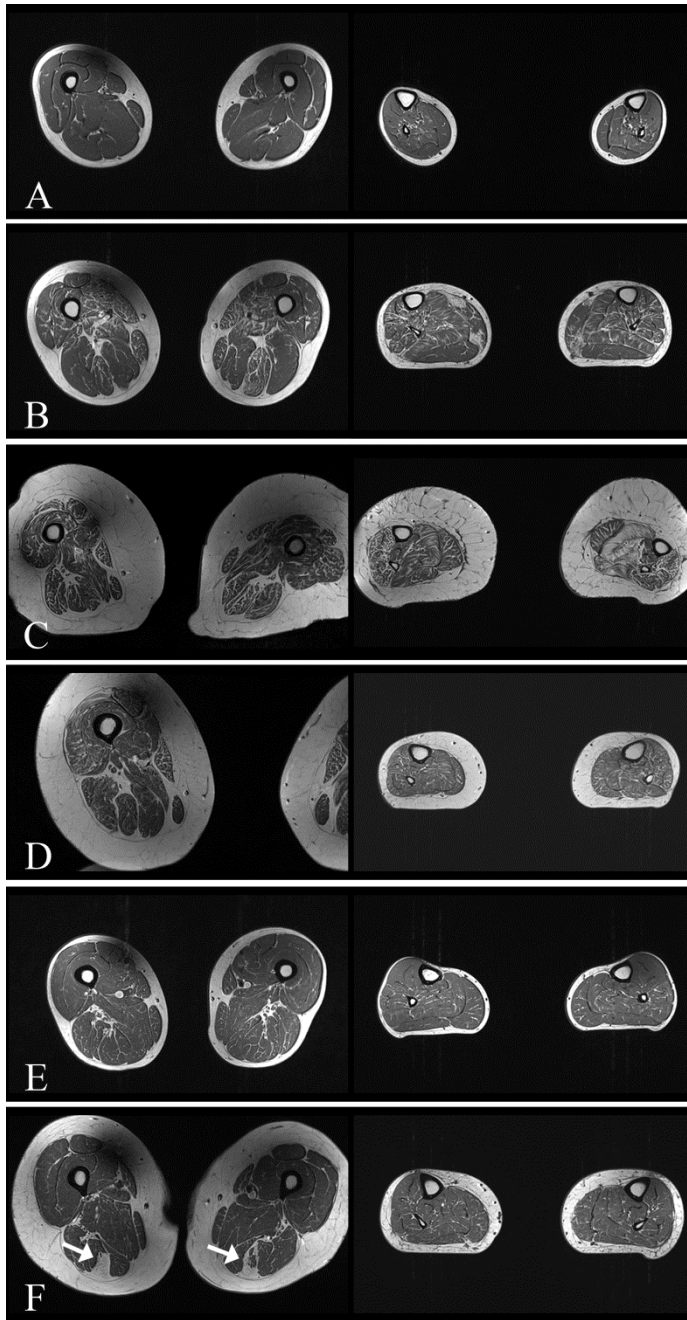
T1w MR images from CMS subjects: Axial thigh images are shown on the left and calf images on the right from individual subjects with (A) AChR deficiency (3), (B) GFPT1 (18), (C) DPAGT1 (21), (D) slow channel syndrome (12), (E) DOK7 (8) and (F) rapsyn (5) CMS. Note the focal areas of fat equivalent to Mercuri grade 4 bilaterally in semitendinosus muscles in F (arrows). Subject ID in brackets. Note the field inhomogeneity artefact that can be seen predominantly affecting the anterior region of the right thigh. This was present to some degree on all scans, though did not significantly interfere with Mercuri scoring.
